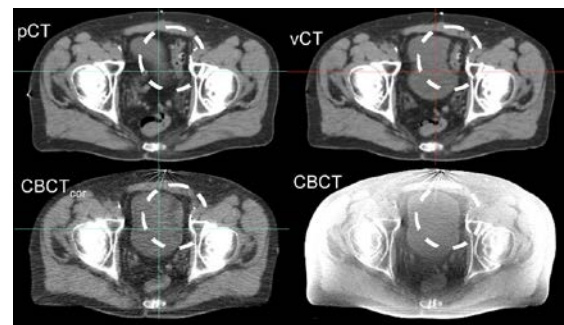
Comparison of vCT, CBCT<sub>cor</sub>, initial planning CT (pCT) and the original CBCT of PatPR3, using the same window for displaying. The original CBCT shows inaccurate
